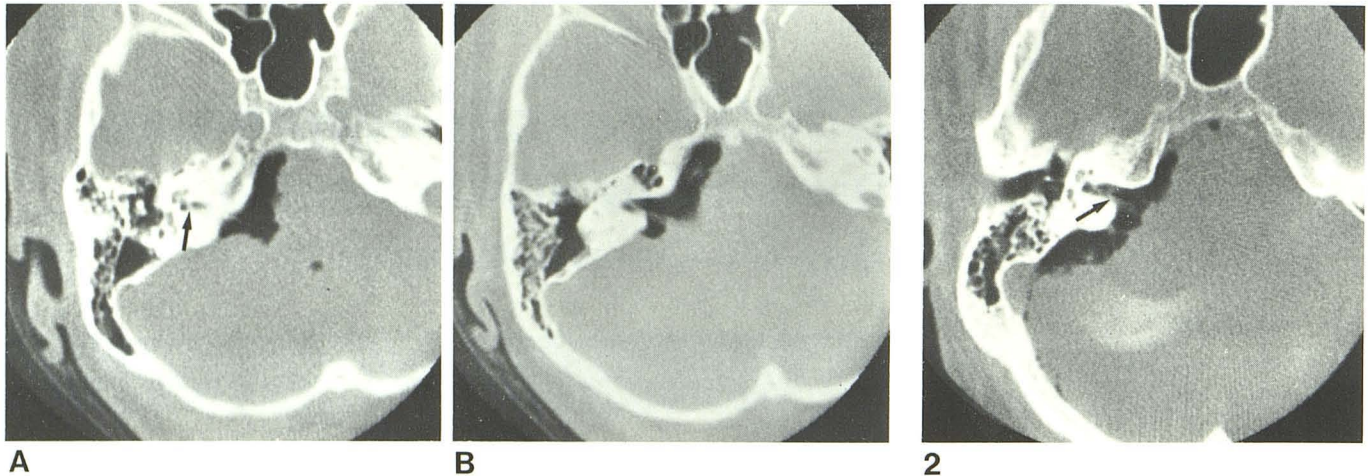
Normal gas CT cisternography. A, Scan cut through inferior aspect of internal auditory canal. Gas in lateral part of canal and within right cerebellopontine angle cistern. Part of neurovascular bundle seen at most lateral aspect of gas in cistern before its entrance into porus acusticus. Linear structure, coursing through tractus spiralis foraminosus to modiolus of cochlea, represents cochlea division of eighth cranial nerve (*arrow*). B, Higher scan cut through midpart of right internal auditory canal. Gas fills entire canal. Neurovascular bundle courses through gas-filled cistern and within internal auditory canal.
